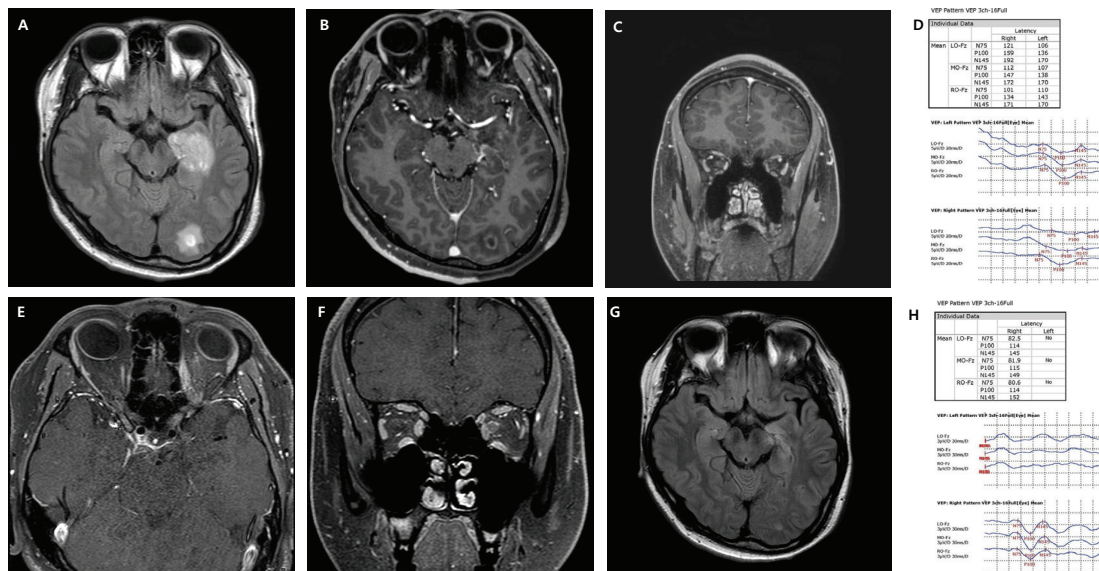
Brain magnetic resonance imaging and visual evoked potential of the case. A: Fluid-attenuated inversion recovery axial imaging at the second attack exhibited a high signal intensity in the left medial temporal and occipital lobes. B: Gadolinium-enhanced T1 axial imaging at the second attack exhibited a peri-ependymal and punctuate enhancement in the medial temporal lobe and peripheral enhancement in the left occipital lobe. C: Gadolinium-enhanced T1 coronary imaging at the second attack exhibited an enhancement in the right optic nerve and sheath. D: Full field visual evoked potential at second attack exhibited a poor wave formations and delayed latencies in both sides. E, F: Fat-suppression gadolinium-enhanced T1 axial and coronary imaging at the first attack exhibited a segmental gadolinium-enhancement in the left optic nerve sheath. G: Follow-up fluid-attenuated inversion recovery axial imaging after the second attack exhibited a decreased and attenuated lesion in the left medial temporal and occipital lobes. H: Full field visual evoked potential at the first attack exhibited an absence of P100 wave in the left side.
